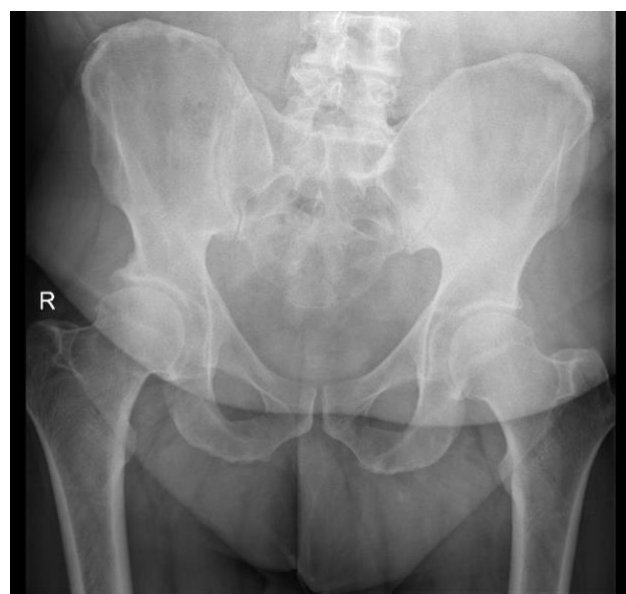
Pre-operative X-ray showing osteoarthritis of the right hip.
